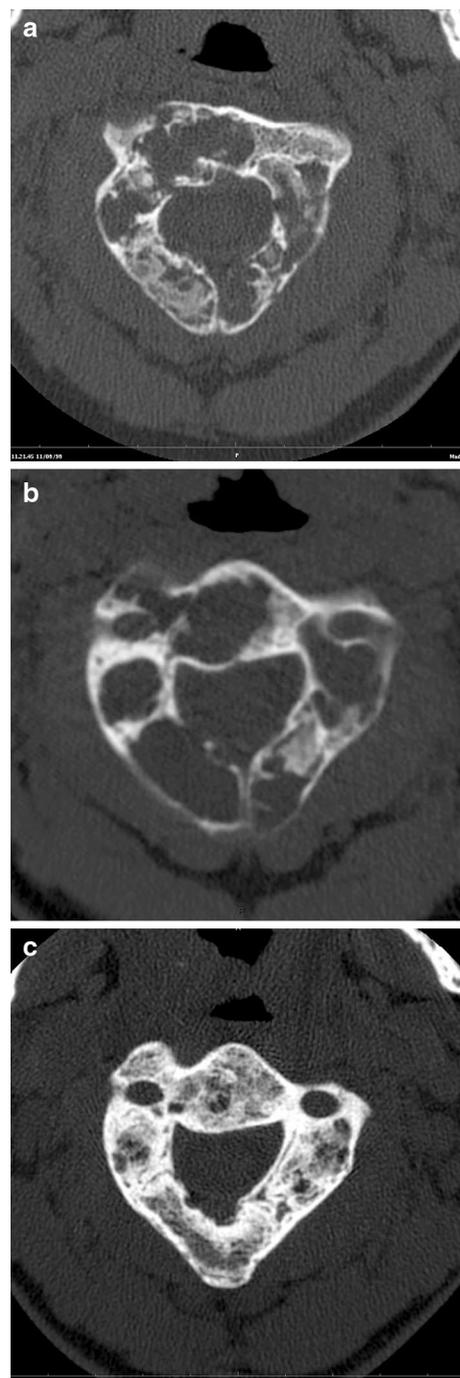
a Trocar biopsy confirmed C2 ABC in a 15-year-old boy. Lytic changes with progressive swelling of the vertebra outline. Moderate pain. b SAE partially effective due to microvascularization by deep cervical artery and vertebral artery. After 10 months of observation, the result is satisfactory from a clinical stand point (no pain, limited reduction of the ROM), but the reconstruction was considered not acceptable and one injection of centrifugate autologous (from iliac crest) bone marrow was performed. c CT scan control 31 months after the CBM injection and 41 months after the diagnosis. One local CBM injection allowed to achieve an excellent local reconstruction
